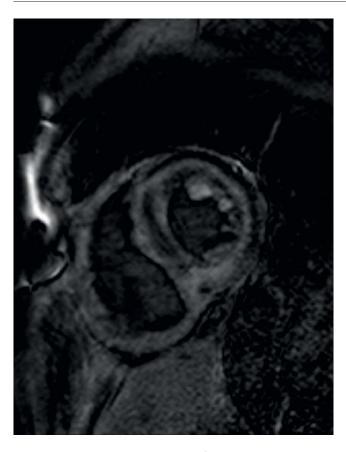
Magnetic resonance imaging of amyloid cardiomyopathy. A typical global subendocardial late gadolinium enhancement of the LV walls is present together with enhancement of RV free wall (short axis view). LV – left ventricle.
